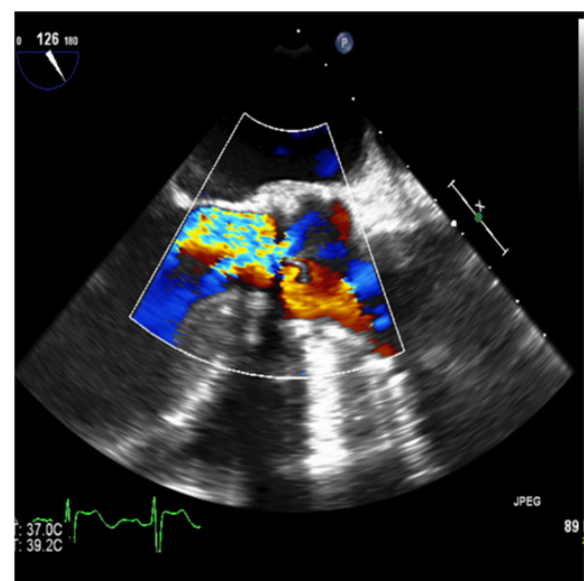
Echocardiogram image showed a color Doppler with a severe aortic regurgitation.
